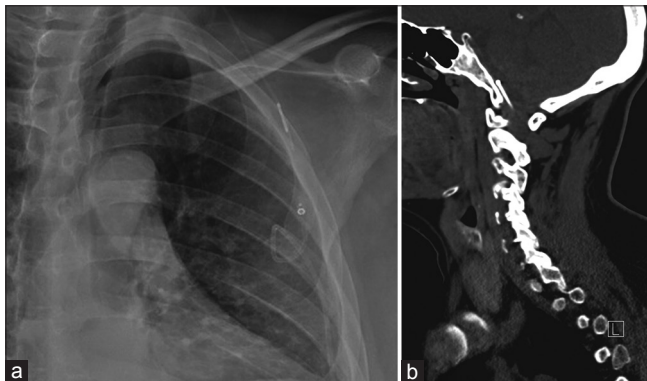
(a) Post-operative sagittal computed tomography reconstruction showing the catheter (arrow) in the generous subarachnoid space of the premedullary cistern. (b) Post-operative anteroposterior chest X-ray showing the placement of the shunt valve in the infraclavicular chest wall (arrow) and distal shunt tubing in the interpleural space (case number 2)
